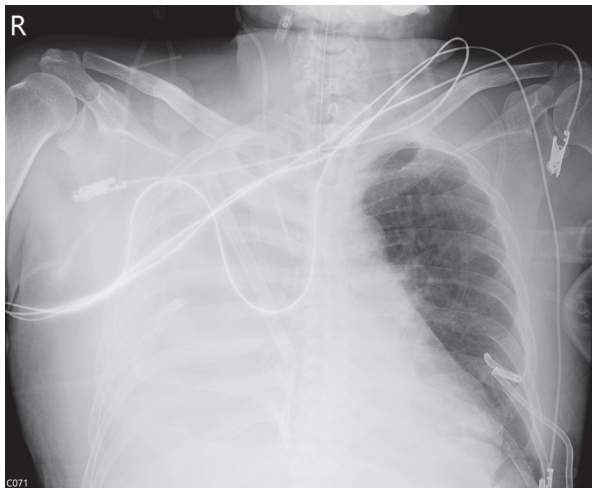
Plain film, POD 7: Massive right-side pleural effusion despite chest tube drainage.
